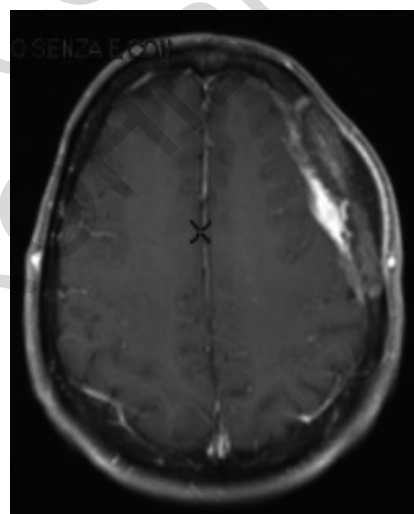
Pre operative axial T1 MRI image.
